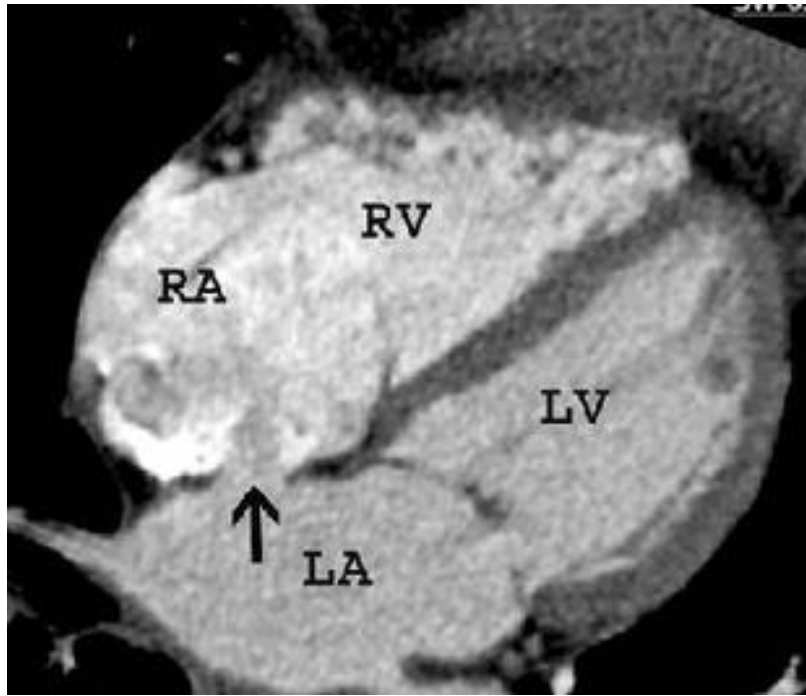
the contrast jet extends from the left atrium to the right atrium in this CT picture showing a defect in the fossa ovalis (arrow) (20).
